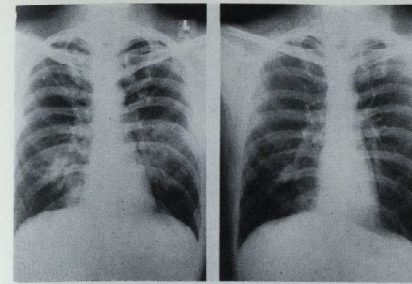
X-Rays of Case 1
